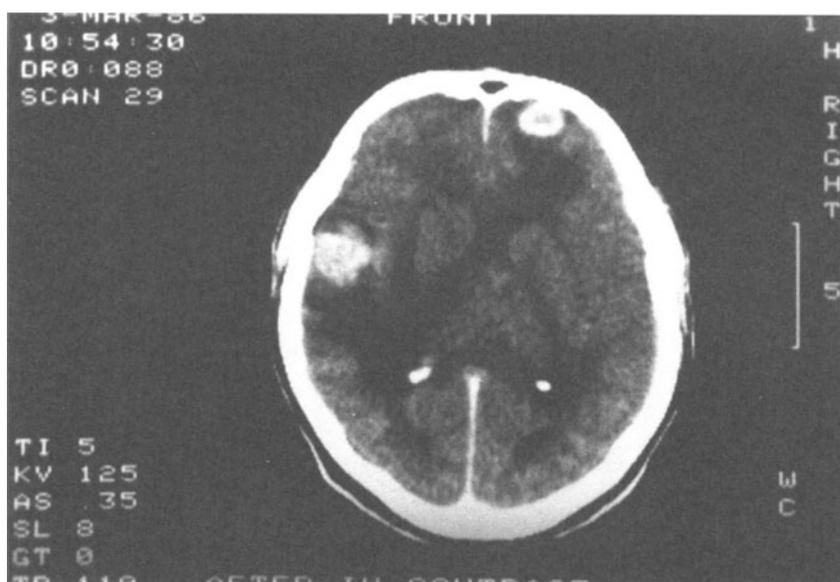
CT scan of 40-year-old taken 6 weeks after commencement of treatment of Stage I meningitis when initial CT scan normal. Multiple tuberculomas present. Resolved with continuation of drug therapy and additional corticosteroids.
